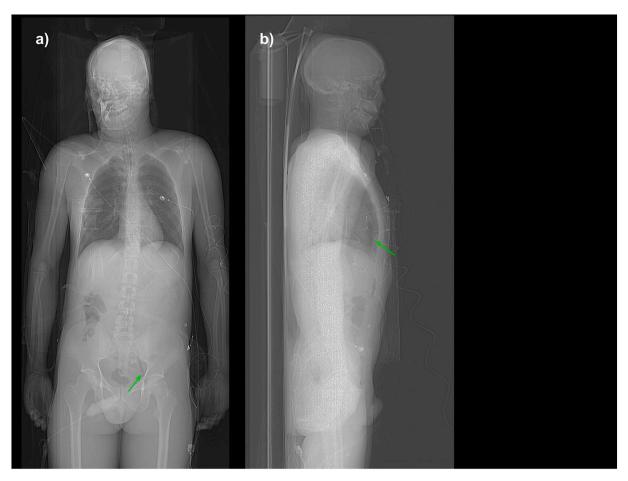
Air emboli of (a) left external iliac vein on frontal view and (b) right ventricle of heart on sagittal view scout CT.
